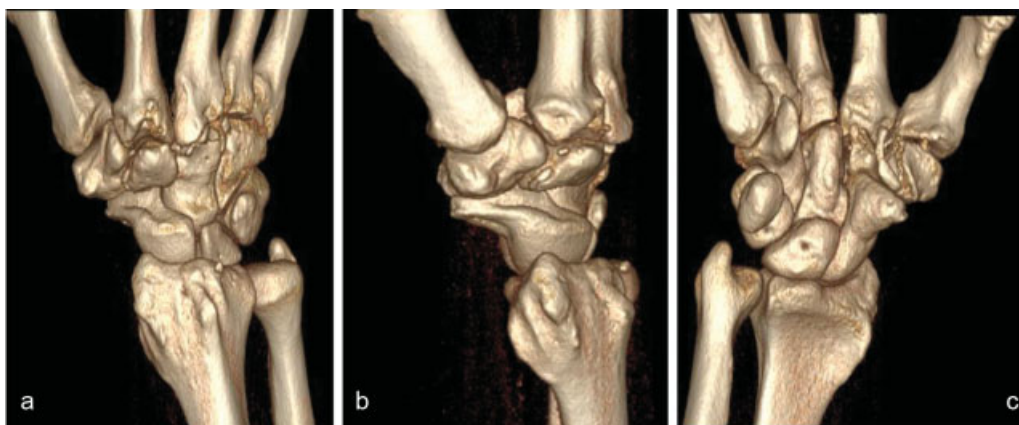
CT scan with 3D reconstructions showing (a) dorsal, (b) lateral, and (c) volar projections of the wrist. Dorsal displacement of the trapezoid with its associated second metacarpal is appreciated particularly in (b). Small volar avulsion fracture on the trapezium is again visualized with subluxation at the STT joint.
